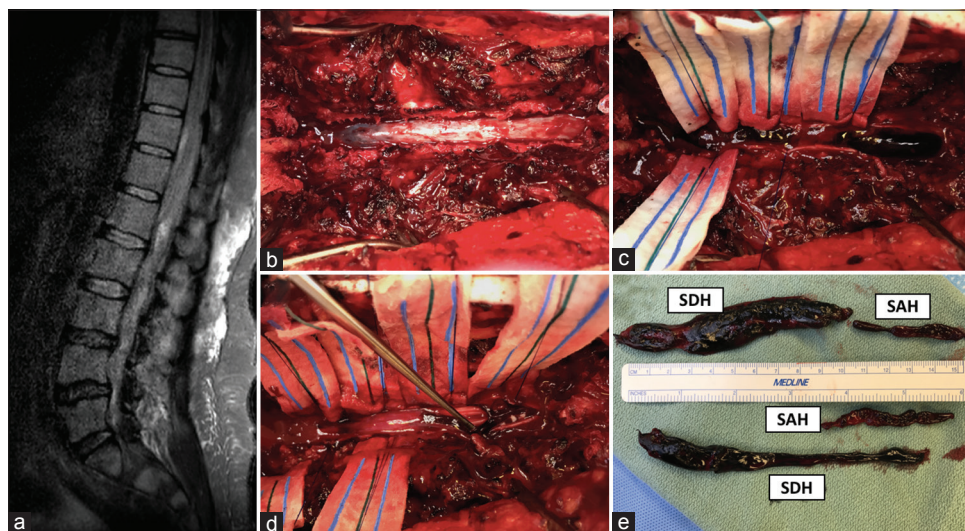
(a) Lumbar plain MRI depicts a large intraspinal hematoma which extends from T11 down to L5 with severe neural compromise. (b) Intraoperative exploration after T11–L3 laminectomy and evacuation of spinal epidural hematoma (not shown in this photo). (c) Giant spinal subdural hematoma was noticed post midline durotomy. (d) Incision of the arachnoid layer was done due to evidence of large subarachnoid clots which were retrieved successfully. (e) Multiple large and thick spinal hematomas from subdural and subarachnoid spaces
